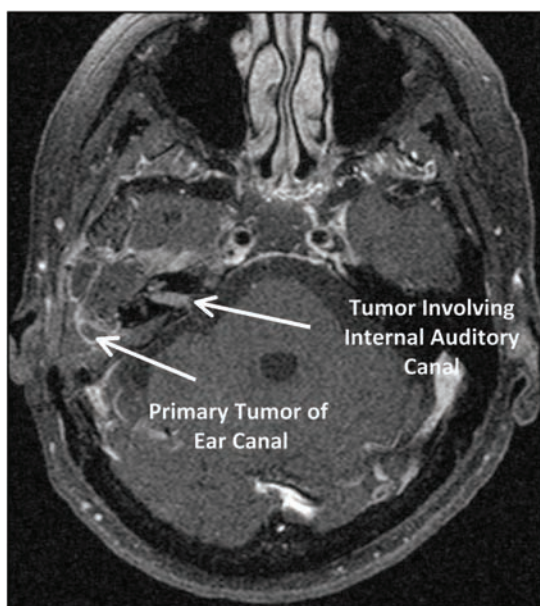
A T1-postgadolinium axial MRI of the internal auditory canal with squamous cell carcinoma of the ear canal. The MRI shows involvement of the internal auditory canal with a tumor, indicating invasion of the facial nerve and intracranial extension.
